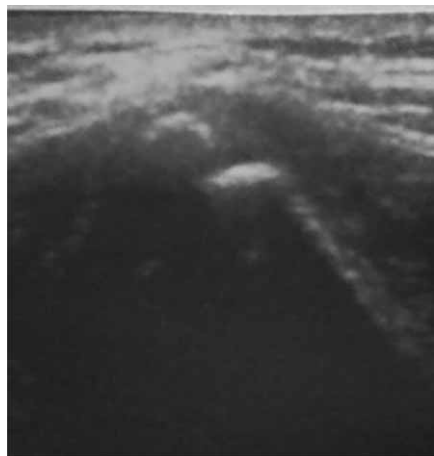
Risser 4a grade: in transverse sonogram of iliac bone, there is 2 mm or more cartilage between iliac apophysis and iliac wing.
